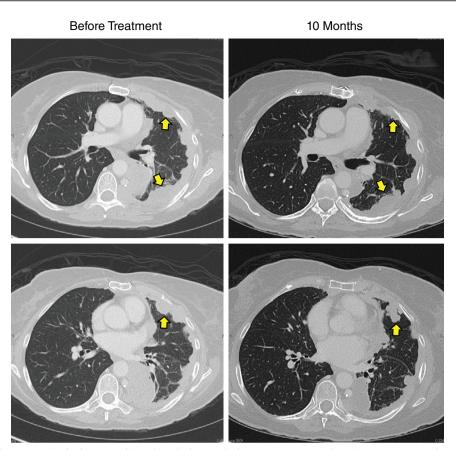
Computed tomography (CT) image of the chest before and after treatment. Baseline chest CT imaging showing extensive metastatic pleural-based nodules on the left (arrows) from metastatic thymoma, and overall stable disease after 10 months on olaparib.
